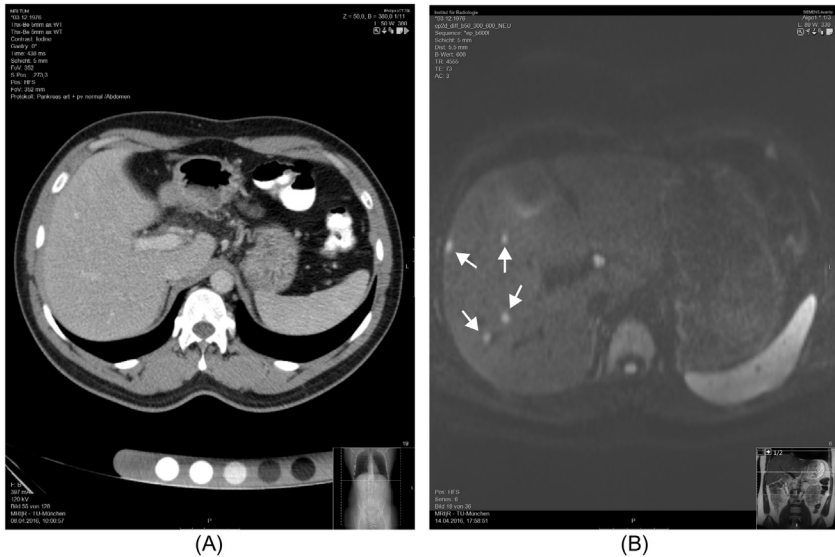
Patient suffering from pancreatic cancer: (A) CT scan: The liver seems to be free of metastases; (B) MRI scan: multiple small lesions are detected (arrows). *All: Courtesy: Dr. A. Fingerle, Klinikum rechts der Isar.*
